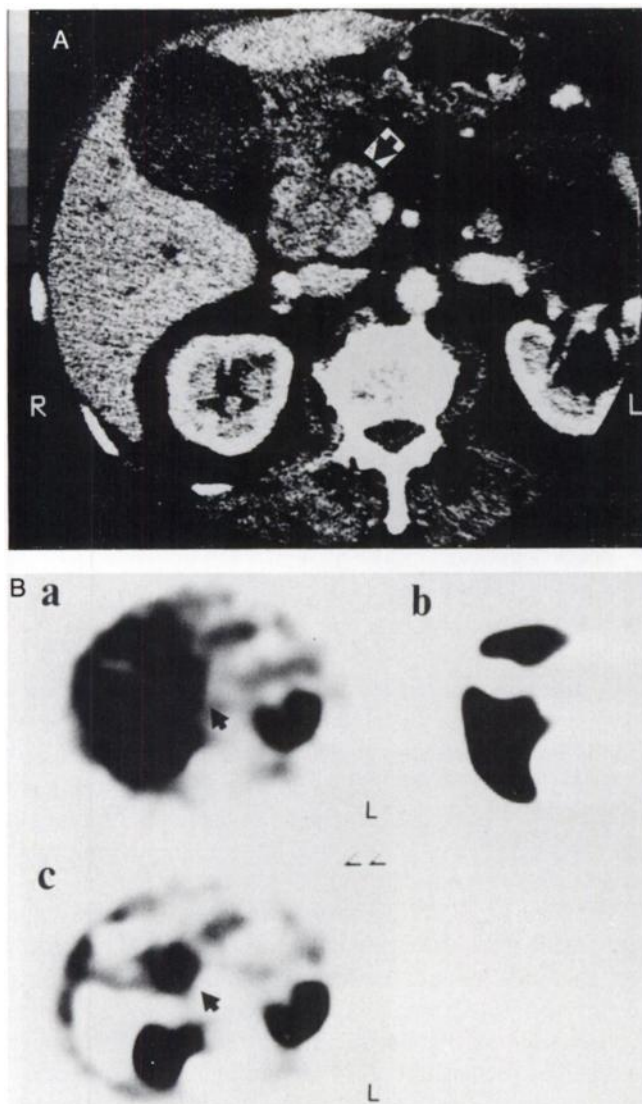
A 79-yr-old male with an adenocarcinoma. (A) Enhanced CT shows a 35 × 30 mm tumor in the pancreas head (➔). Secondary dilatation of the pancreatic duct is seen in the caudal portion. (B) On the ^{201}Tl SPECT image (a), the boundary of ^{201}Tl uptake in the tumor (➔) was not clearly distinguished from liver activity. In contrast, the subtracted SPECT image (c), which was obtained using the $^{99\text{m}}\text{Tc}$ -phytate image (b), subtracts the liver and an abnormal uptake site was clearly visualized (➔). The L/H ratio acquired on the ^{201}Tl SPECT image (a) was 0.81. Incidentally, no clear abnormal uptake was noted in the caudal portion of the pancreas.
